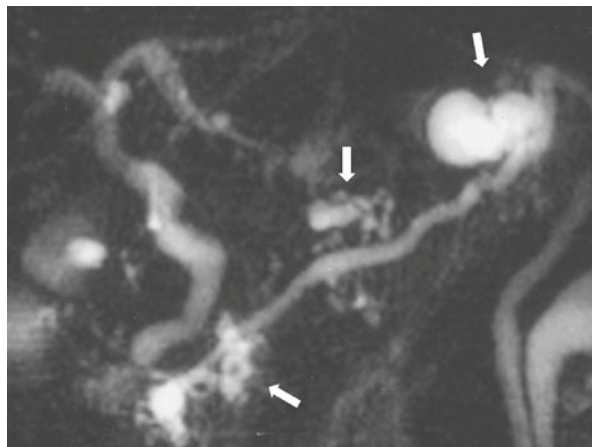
Radiological images of mixed-type IPMN. (a) MRCP clearly delineating segmental dilation of the main pancreatic duct combined with a BD-IPMN. (b) CT scan demonstrating only multilocular dilated branches. (c) Endoscopic retrograde pancreatogram showing localized segmental dilation of the main pancreatic duct in the tail of the pancreas but no sufficient visualization of the dilated branch duct
